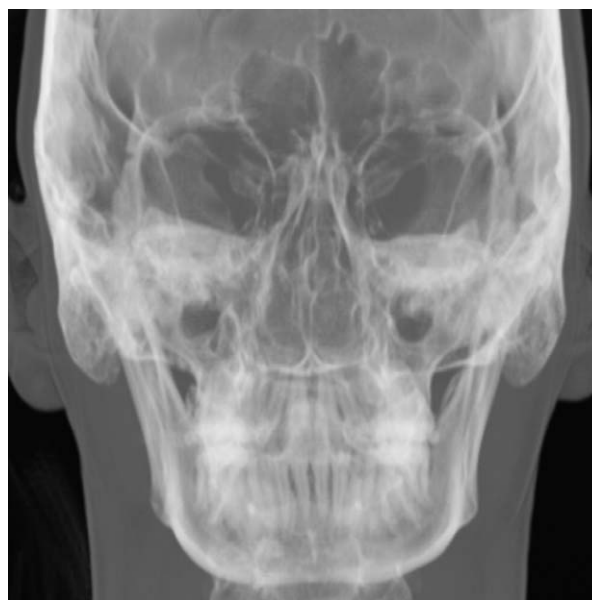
Close-up view of virtual frontal cephalogram (MS-CT).
